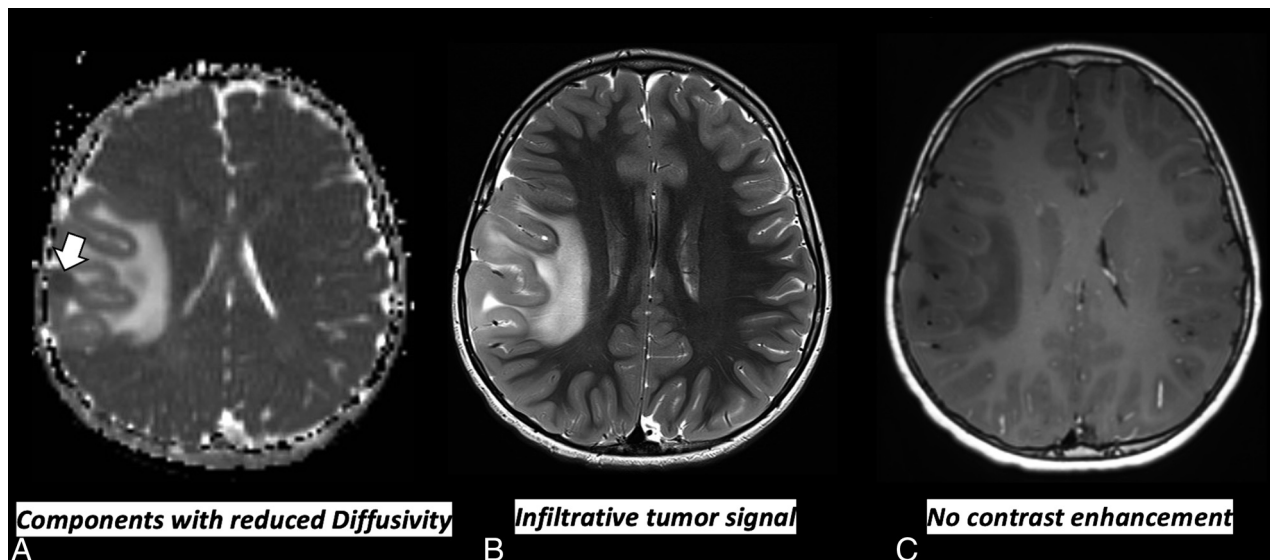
Eight-year-old with *EGFR* altered H3 wild-type and IDH wild-type. ADC map, T2-weighted, and T1-weighted postcontrast axial images of the brain show an infiltrative tumoral signal involving cortex and subcortical matter of the right parietal lobe. These images show a focus of decreased diffusivity (white arrow).
